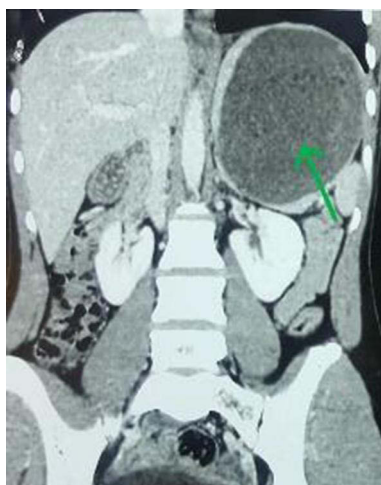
Coronal CT image showing a giant infected splenic hydatid cyst (green arrow). The cyst demonstrates a detached germinal layer, resulting in the loss of the classic multiloculated or “water lily” appearance.
